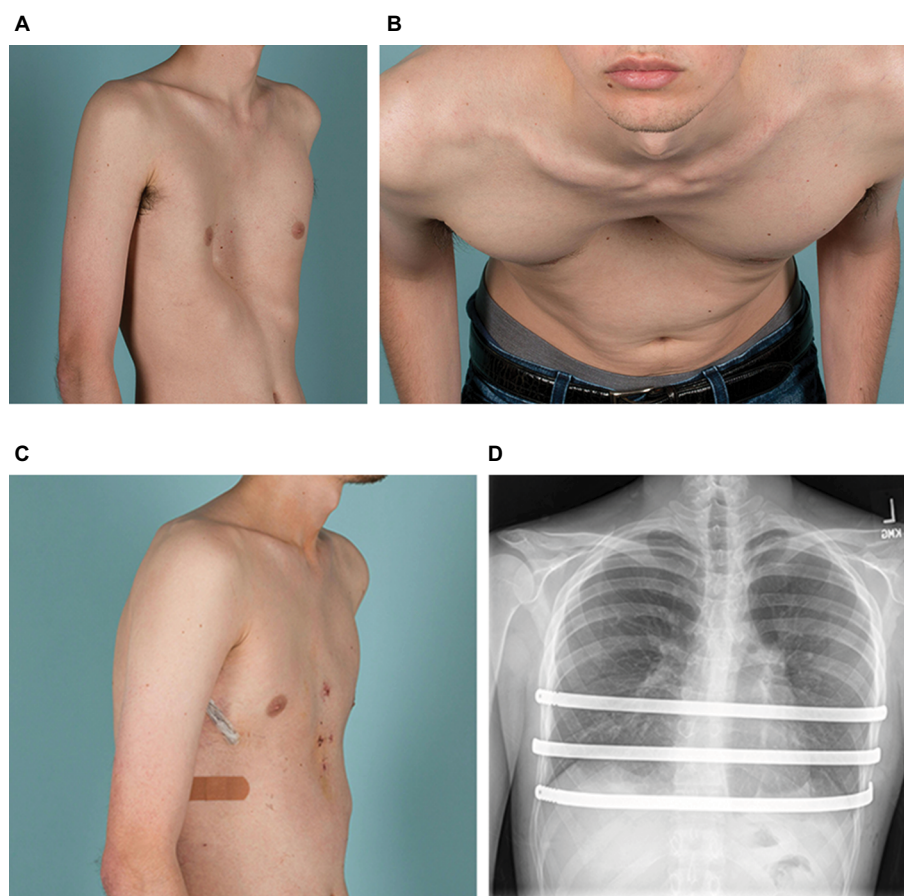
Clinical photographs of a 22-year-old man with severe pectus excavatum are shown before surgery (A, B) and after (C) minimally invasive repair of pectus excavatum, with placement of three Nuss bars as shown in the chest roentgenogram (D).
